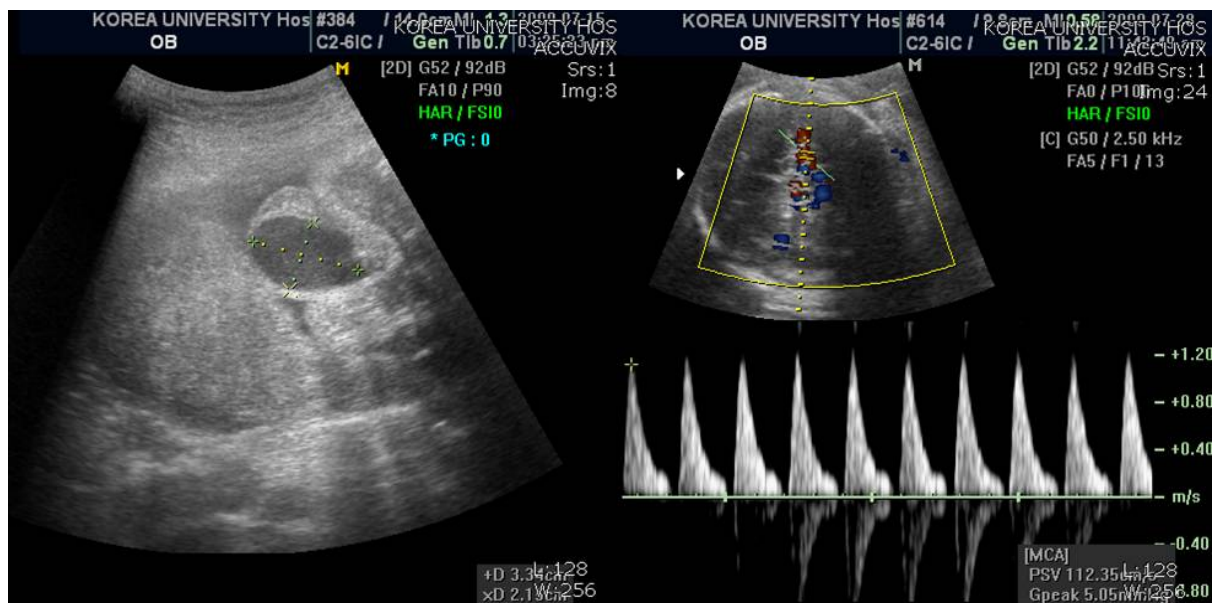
Ultrasonography at the 30 weeks 6 days of gestation shows scrotal swelling and increased peak systolic velocity of the median cerebral artery (MCA PSV).
